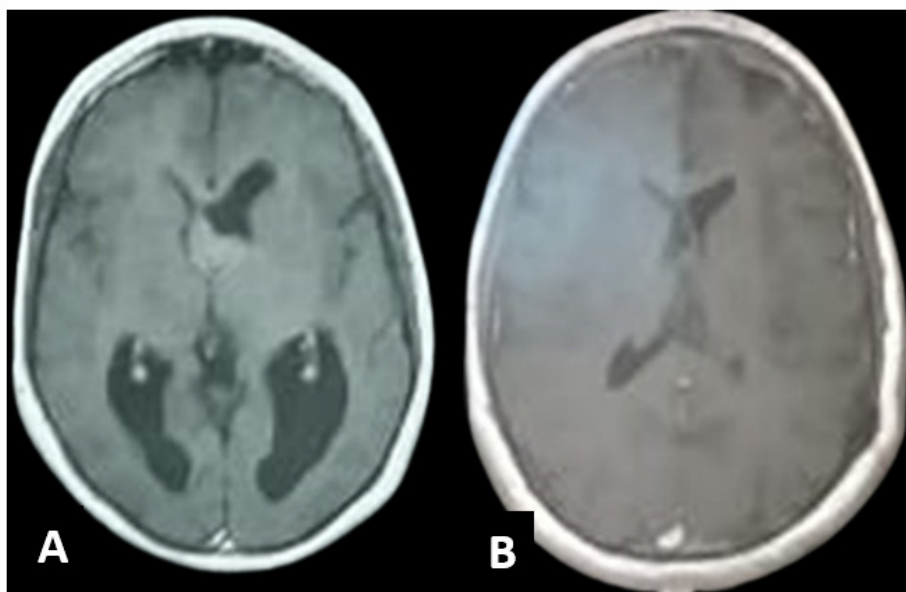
(A) Pre-operative axial MRI with contrast showing an enhancing intraventricular space occupying lesion with associated ventricular dilatation and (B) Post-operative axial MRI with contrast (at 3 months follow up) showing gross total resection of the lesion.
